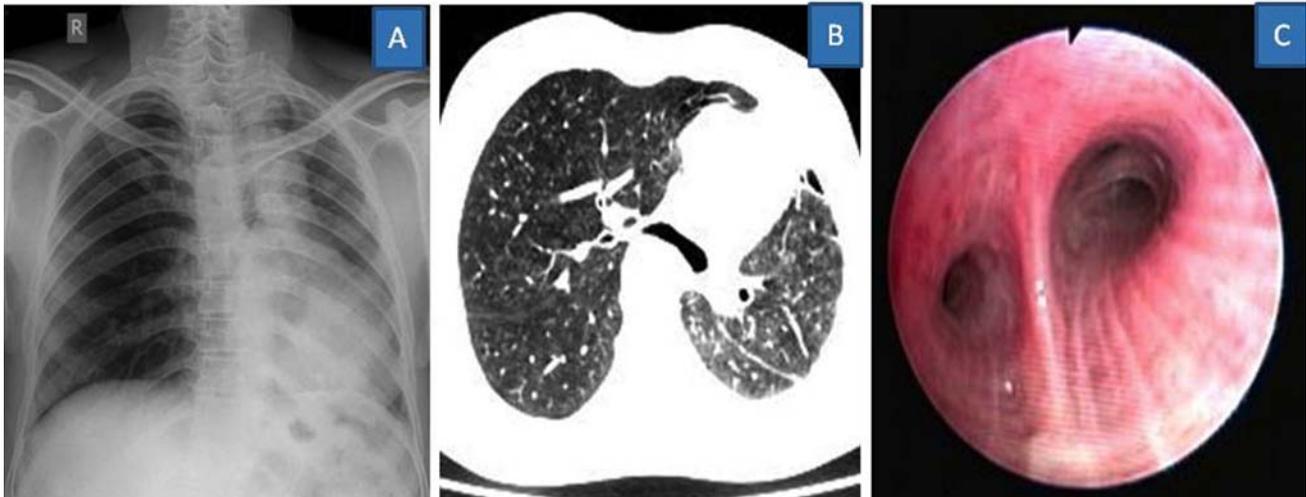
(A) Chest radiograph (postero-anterior view) showing veiled opacity in left hemithorax with shift of the mediastinum to the same side and both the diaphragms at the same level; (B) axial CT thorax at tracheal bifurcation level showing hypoplastic lung parenchyma on the left side; and (C) bronchoscopy image showing the small caliber opening of the left main bronchus.
